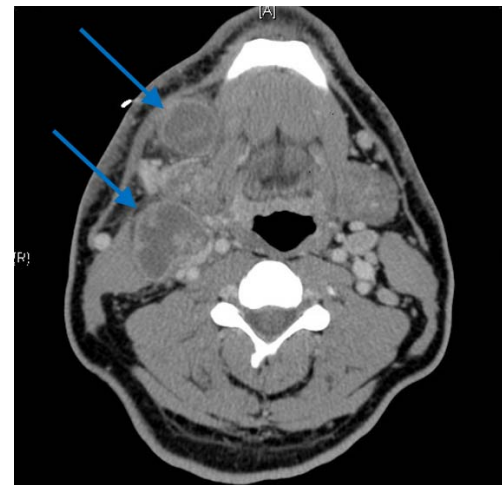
Pathologically enlarged lymph nodes with central necrosis (arrows) are demonstrated on this contrast enhanced CT of the neck. In a young adult without a history of smoking or alcohol abuse, there is increased likelihood that this is HPV related which tends to have a better prognosis. Image courtesy of the University of Massachusetts Medical School, Department of Radiology.
